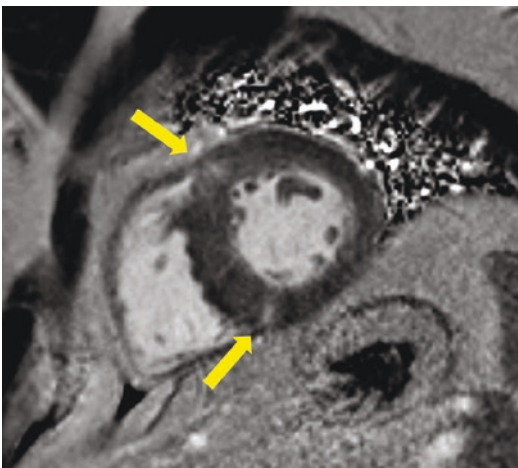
Short-axis MR image of right ventricle showing gadolinium enhancement (fibrosis) of right ventriculo-septal insertion point (see arrows). (Courtesy: Nikolaos Tzemos, MD)
